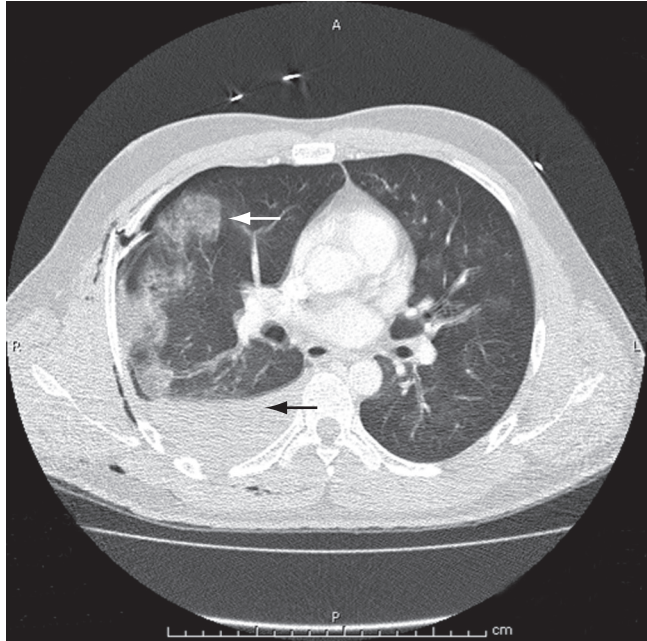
Rib fracture resulting in pneumothorax, with associated hemothorax (bottom arrow) and pulmonary contusion (top arrow) seen on chest computed tomography (CT) scan.
